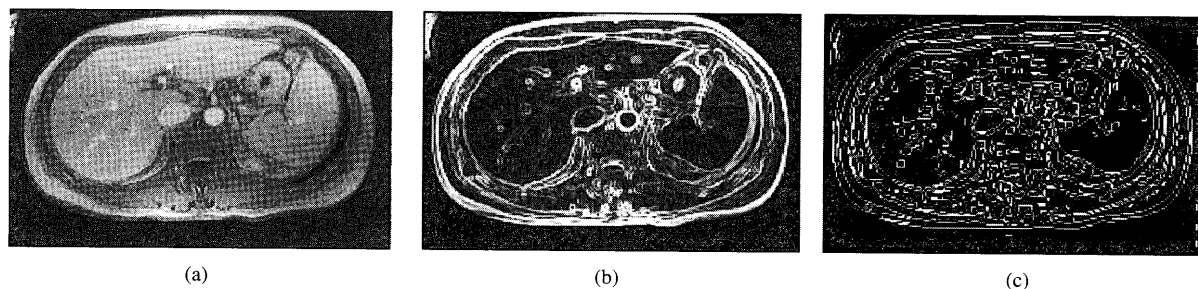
(a) Preprocessed image $I(x, y)$ derived by smoothing and diminishing from original MR image. (b) Magnitude image by using Sobel filter. (c) Binary image after processing (b) by LOG algorithm.
